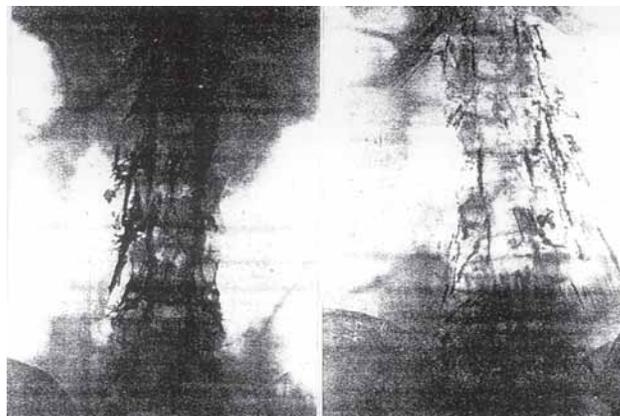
Roentgenographs of the lumbar spine showing the distribution of a mixture of lipiodol (50%) with olive oil, injected epidurally by Gutierrez. Photographs of films taken 5 minutes (left) and 30 minutes (right) after injection.
